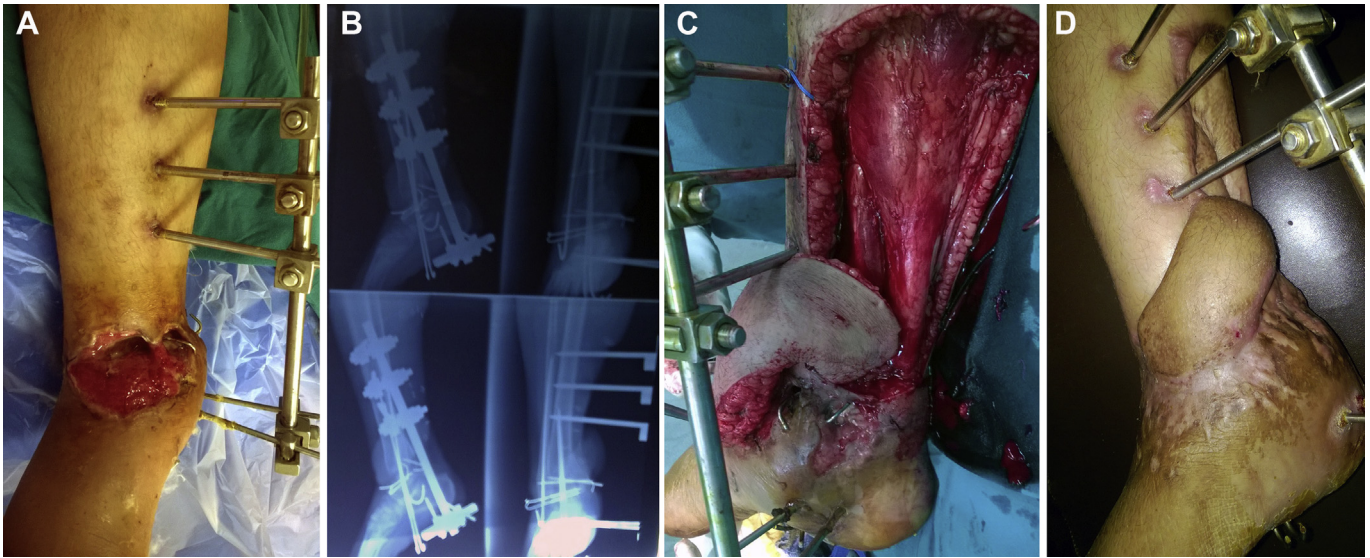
Severe trauma to the lower third of leg and ankle joint with exposure of bone and hardware and coverage by posterior tibial artery perforator flap. A: Exposure of bone and hardware; B: X-ray showed multi fragmentary fracture with multiple fixation; C: Rotation and in setting of the flap; D: Complete healing of the flap (5 months postoperative).
